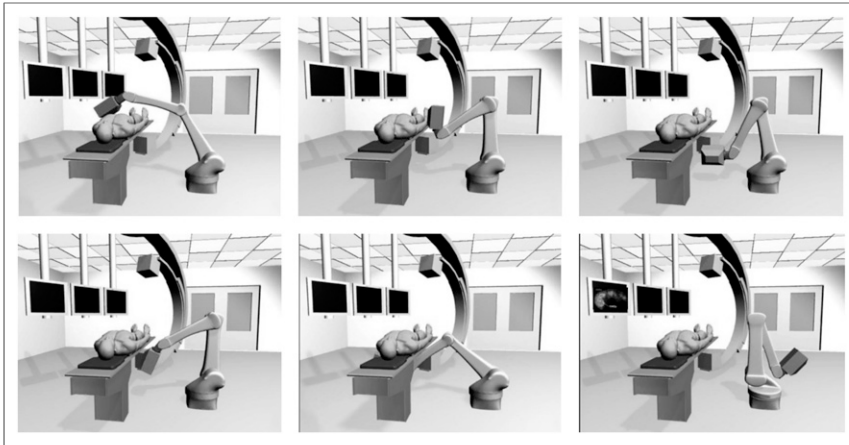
Interventional pinhole SPECT camera mounted on 6-axis arm robot (58). The images show how the robotic gantry is able to acquire tomographic images from multiple angles.
